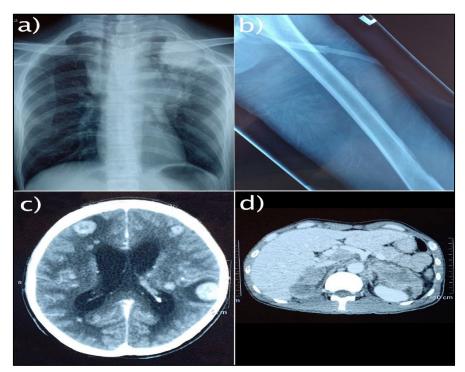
(a) Plain chest radiograph showed cannon ball like lesion at left lung apex (b) Plain radiograph of left femur showed destructive mass (c) Axial cut CT brain showed multiple brain metastatic lesions (d) Axial cut CT Abdomen showed bilateral adrenal mass
